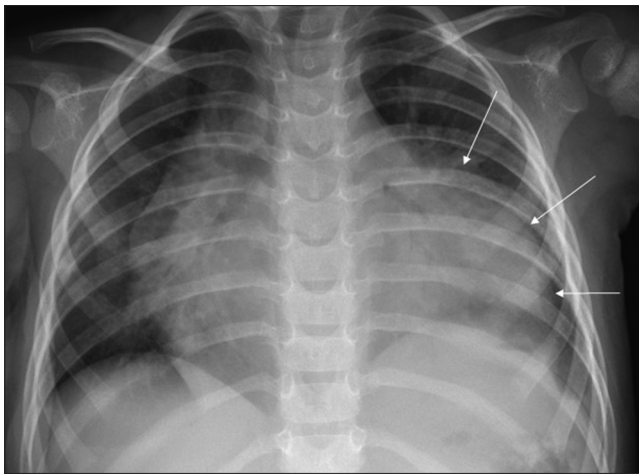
Frontal chest radiograph, large pericardial mass (arrows) occupying lingular region of the left lung
